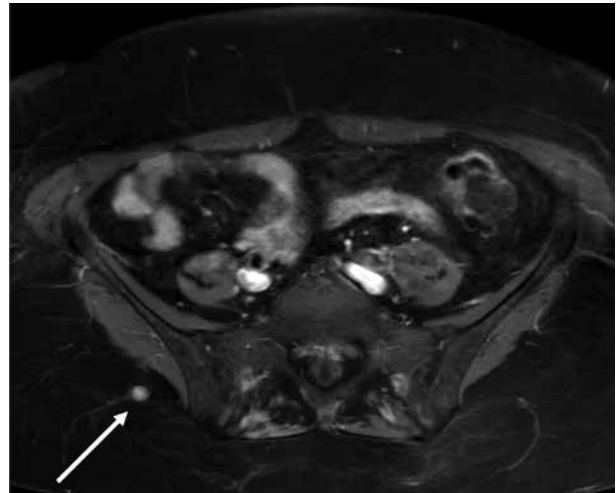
Magnetic resonance imaging of the pelvis highlighting a rounded soft tissue lesion centered in the deep subcutaneous fat adjacent to the proximal right gluteus medius muscle.
